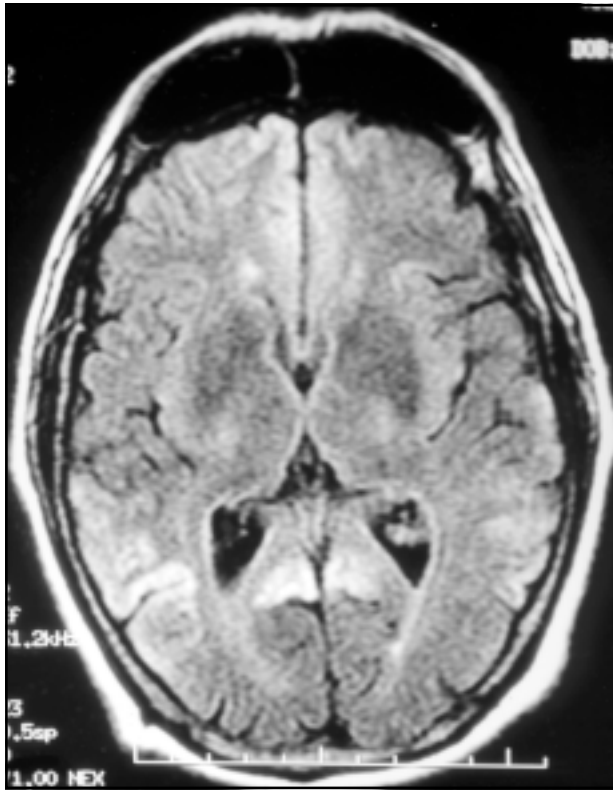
Axial FLAIR image (TR/TE 10002/170) through the basal ganglia demonstrates slightly increased signal in the temporal, mesial occipital e frontal lobes bilaterally, more noticeable over the right cortical ribbon.
